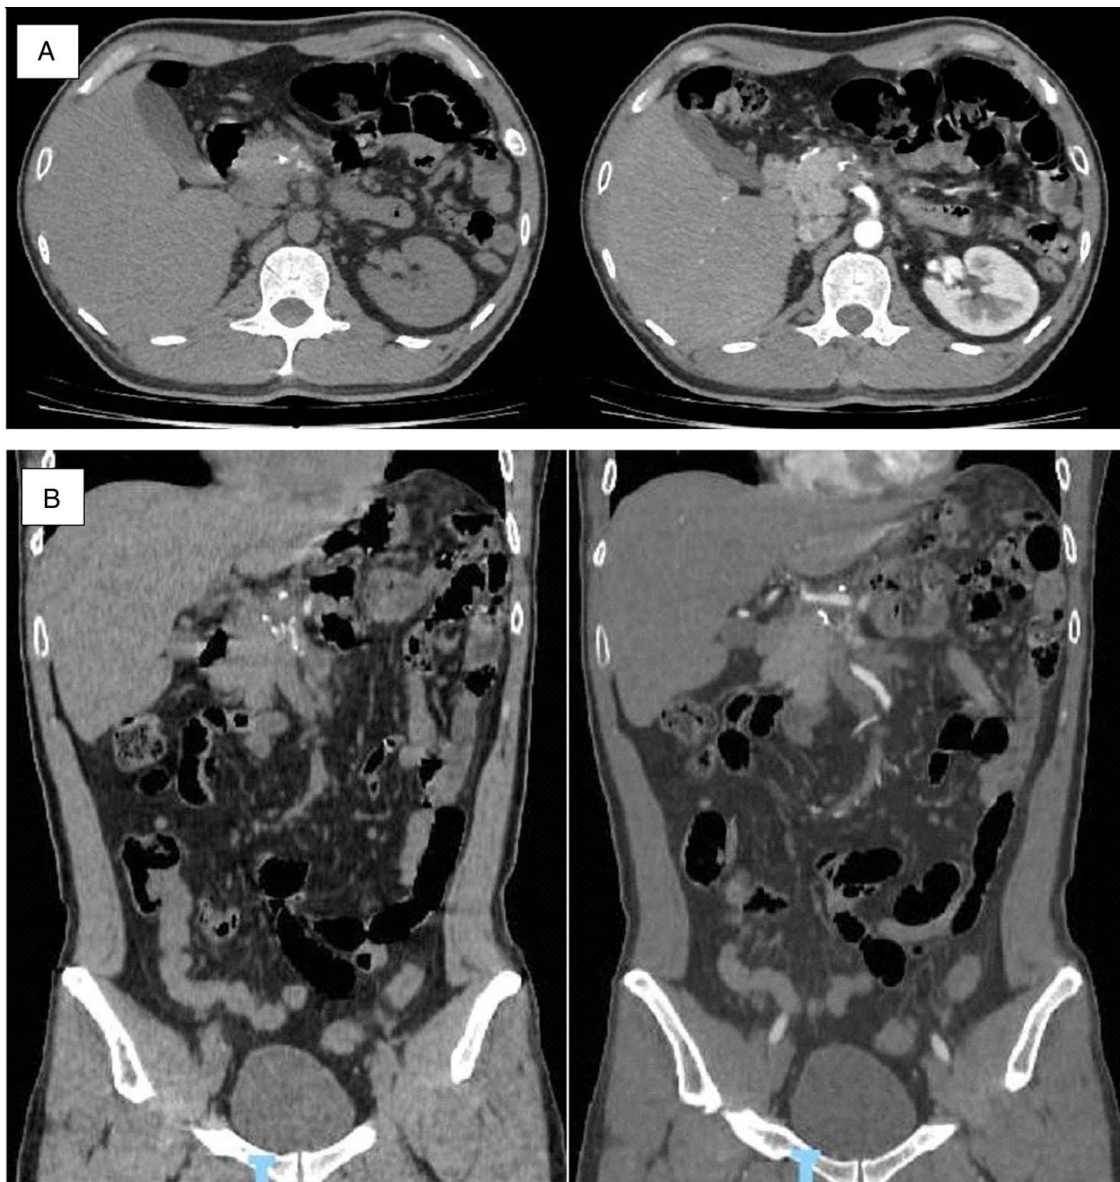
Axial (A), coronal (B) abdominal computed tomography pre-contrast (left) and post-contrast (right) arterial phase.
